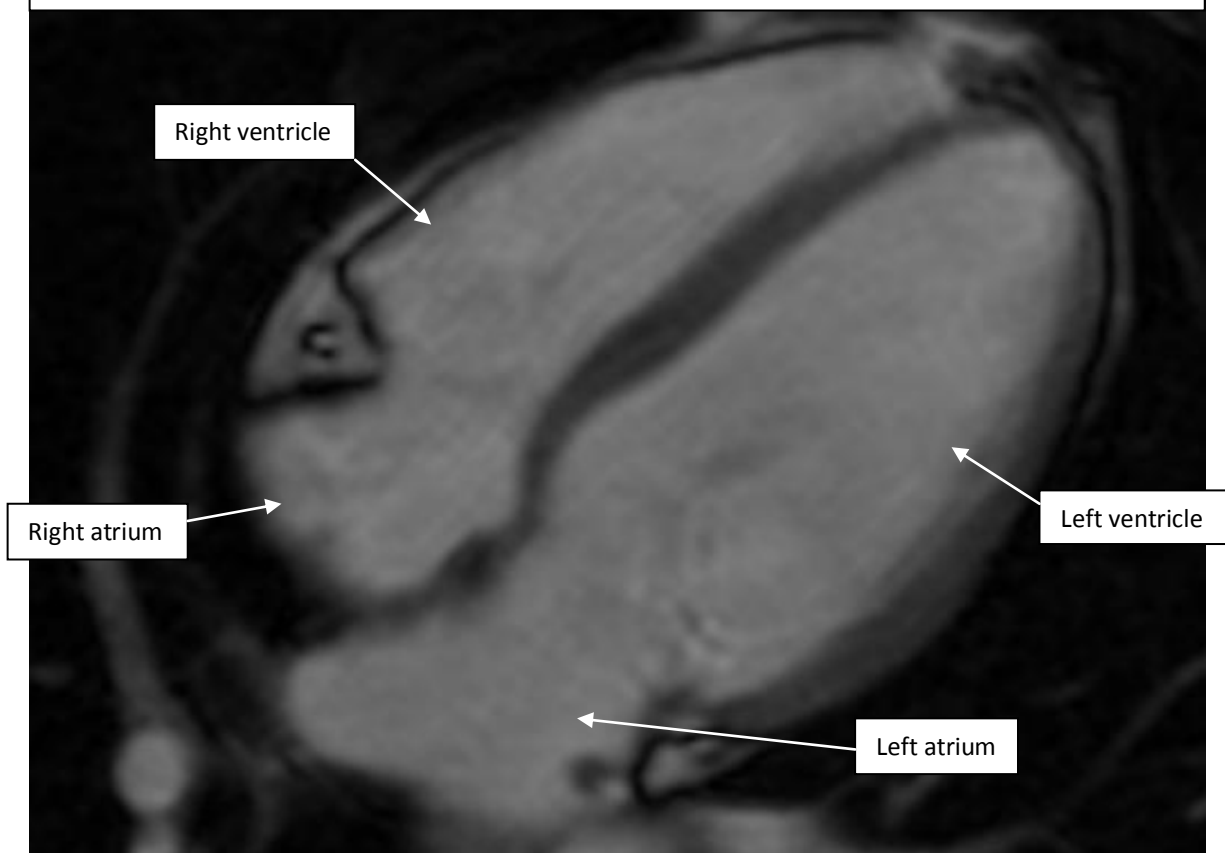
MRI CINE four chamber (horizontal long axis) view at diastole
